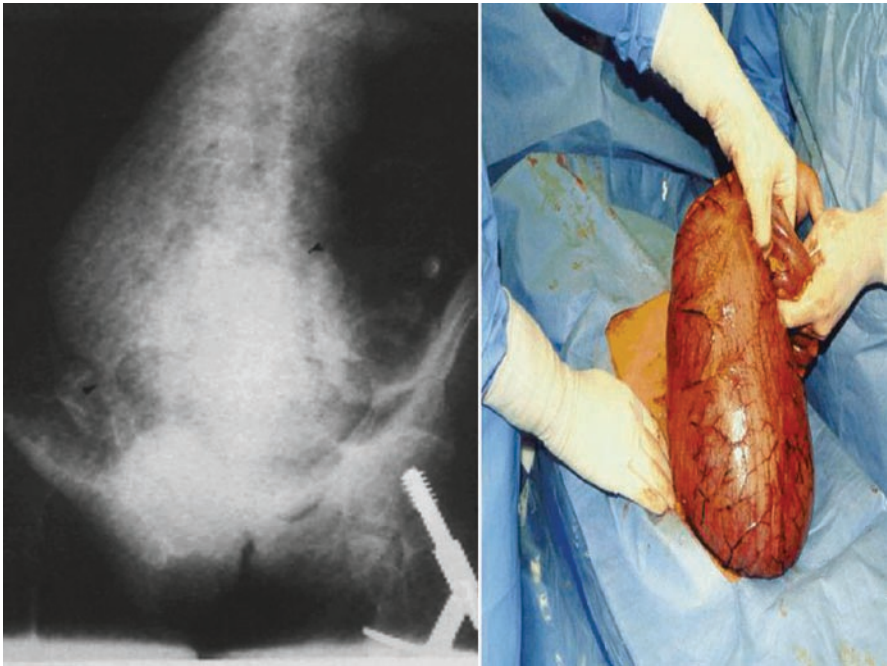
Abdominal X-ray showing a massively dilated rectosigmoid and the corresponding findings at operation
